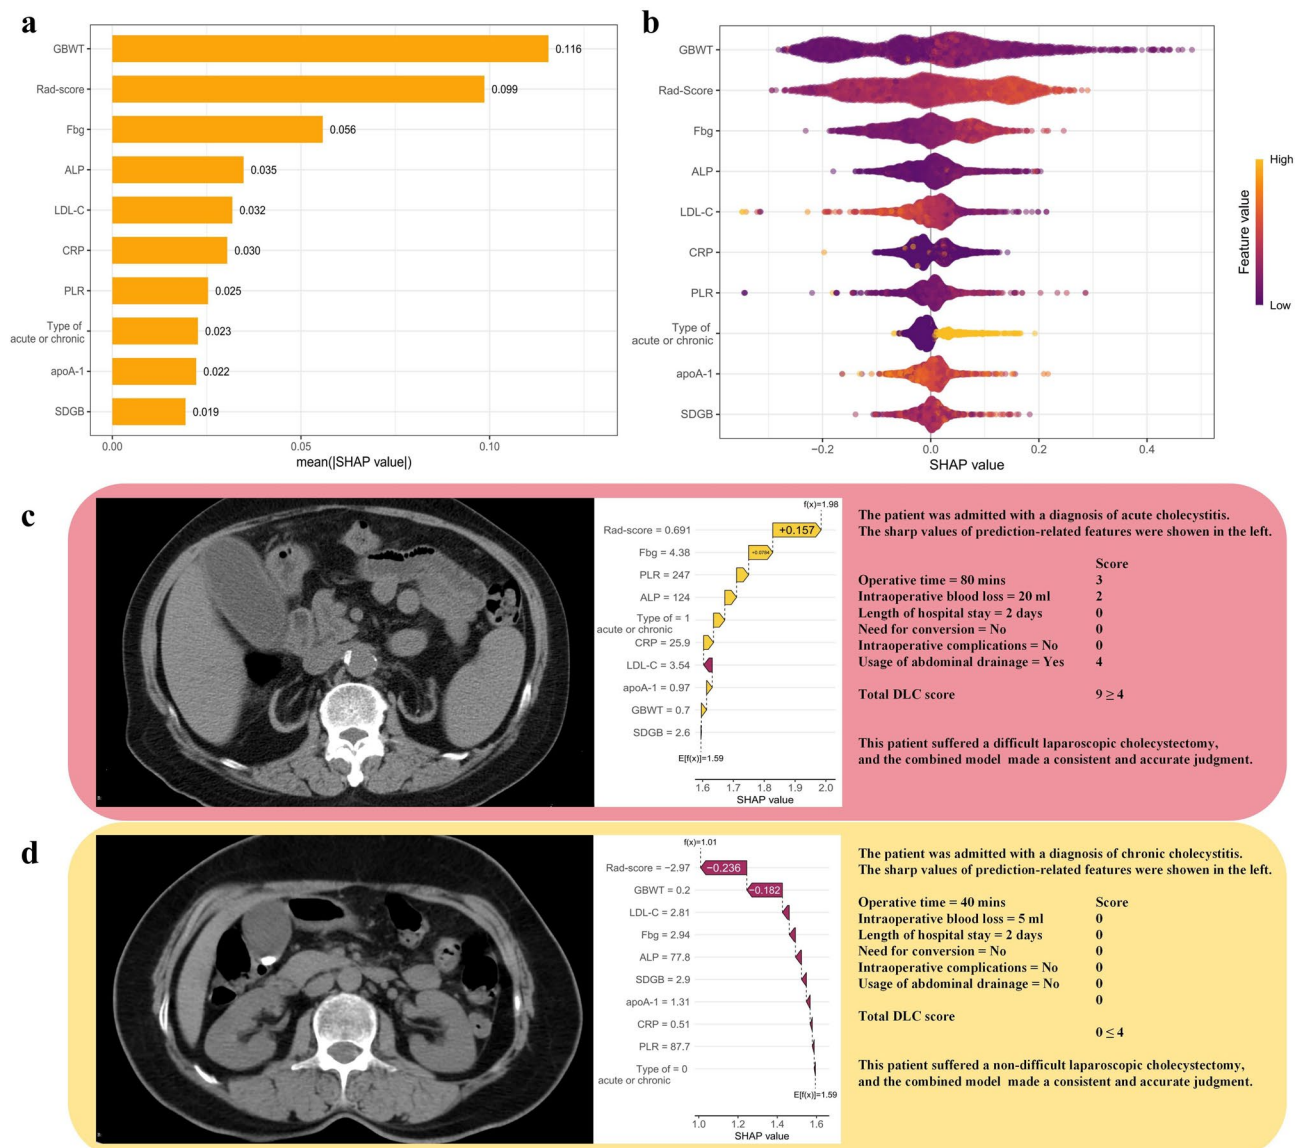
The SHAP value of features maintained in the final combined RF model (a), (b). The original CT image, clinical data, and corresponding SHAP values for a representative DLC patient (c) and a representative NDLC patient (d)
